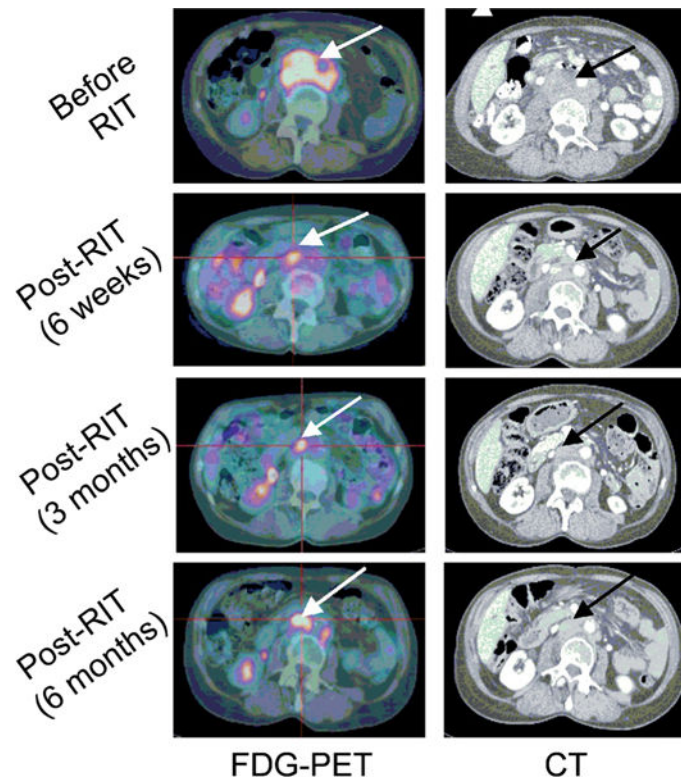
FDG PET for monitoring the response to RIT with ^{90}Y -epratuzumab. FDG PET and CT imaging were performed before and after RIT. Pretreatment images show the involvement of a lumbar lymph node (*arrow*). At 6 weeks and 3 months after treatment, the FDG PET images show a partial response. The CT images show a reduction in lesion mass by 65 % and 80 %, respectively. At 6 months after treatment, the FDG PET image indicates disease progression, while the CT image still shows a substantial reduction in lesion mass (84 %). Reprinted with permission [126]
